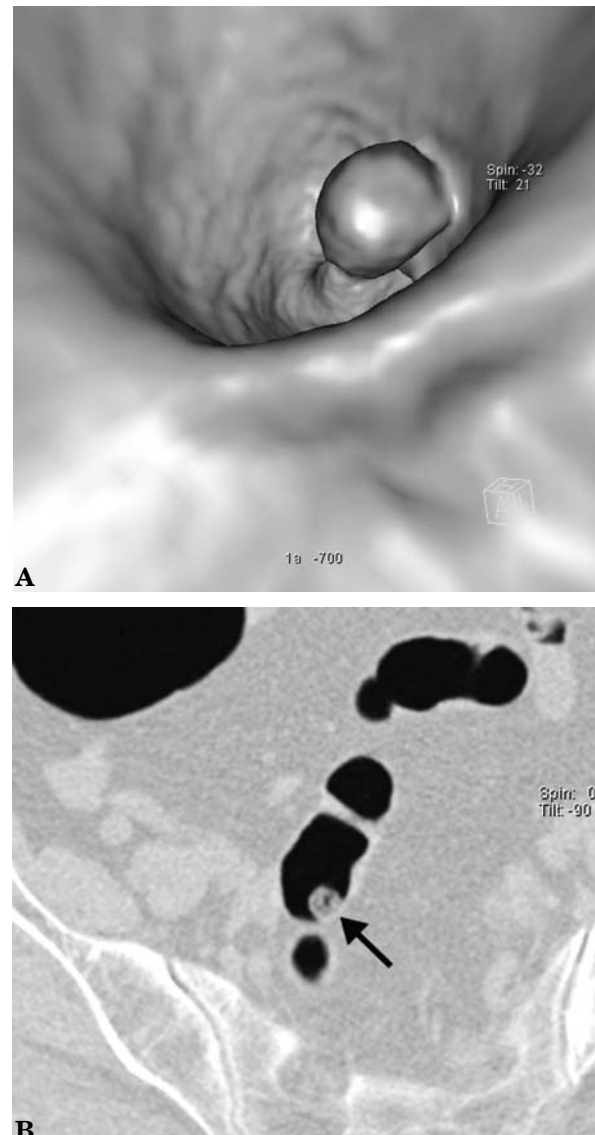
A) Virtual colonoscopy image shows a polypoid lesion in the sigmoid colon. B) Wide-window-setting axial CT image showed air density in the lesion, diagnosed as residual stool. Conventional colonoscopy verified that there was no lesion in this segment
